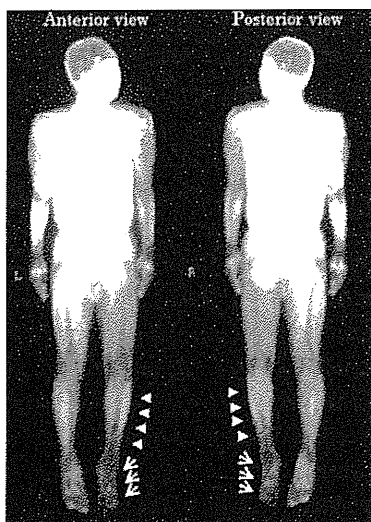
Representative image of ^{99m}Tc-TF perfusion scintigraphy. Arrow-heads indicate lower leg region, and arrows indicate foot region of ischemic leg.
